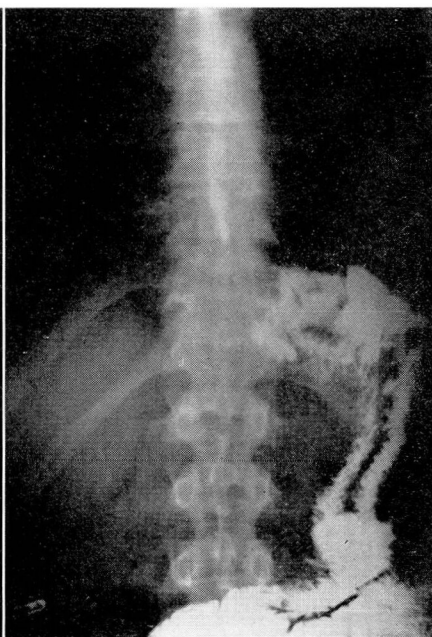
Postoperative roentgenogram showing esophago-enterostomy following total gastrectomy for carcinoma.
